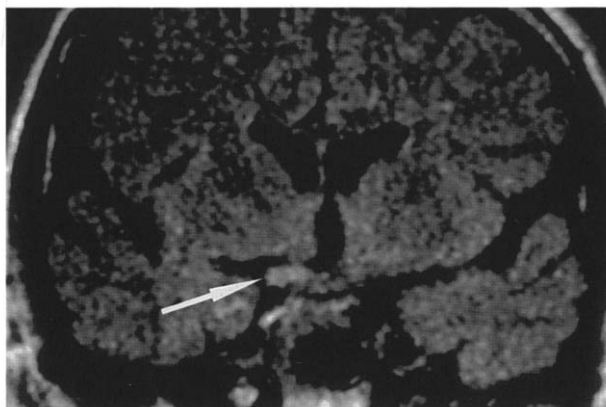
Coronal fluid-attenuated inversion-recovery MRI image of brain through optic tract. Arrow indicates right optic tract, which is bright and enlarged.
